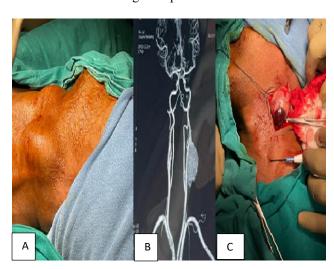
(A-C): Carotid body tumour swelling in the left submandibular region, CT angiogram report showing carotid body lesion and hypervascular carotid body tumour excision.
